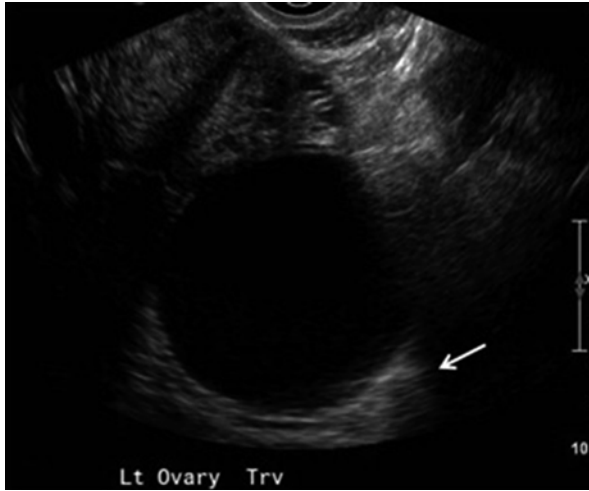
Simple/follicular ovarian cyst. Transvaginal ultrasound demonstrates an anechoic 6-cm cyst with a thin wall and posterior acoustic enhancement (*arrow*) (Reprinted from Amirbekian and Hooley [51], with permission from Elsevier)
